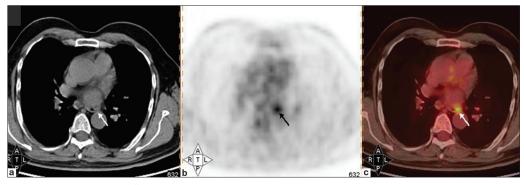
(a) CT, (b) PET and (c) ¹⁸F-FDG-PET/CT scan images of the patient, showing the increased uptake of FDG in the pulmonary nodule (arrow)
